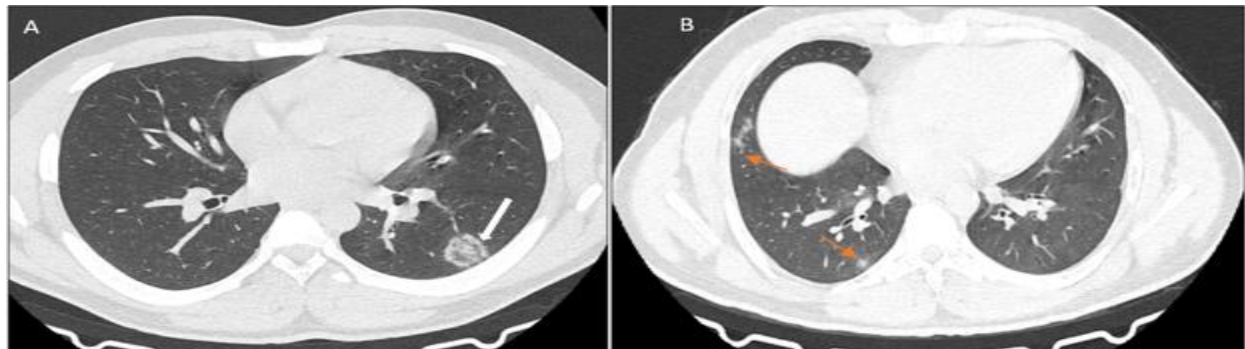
Axial section through HRCT chest in 36-year-old patient reveals (A) rounded subpleural GGO with reverse halo (white arrow) in superior segment of left lower lobe and (B) patchy subpleural GGO (orange arrow) in the basal segments of right lower lobe in the same patient
